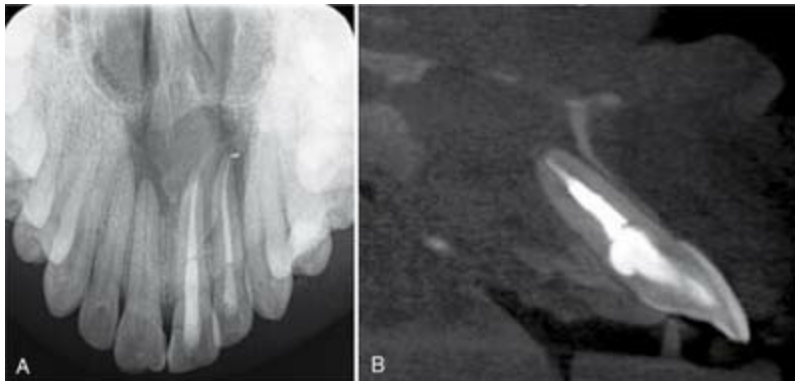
A, An occlusograph showing root fillings in teeth #9 and #10 in a 44-year-old male 25 years after the teeth had been traumatized. Symptoms and infection returned after endodontic treatment and surgical correction was required. B, CBCT imaging revealed internal resorption within the canal.
